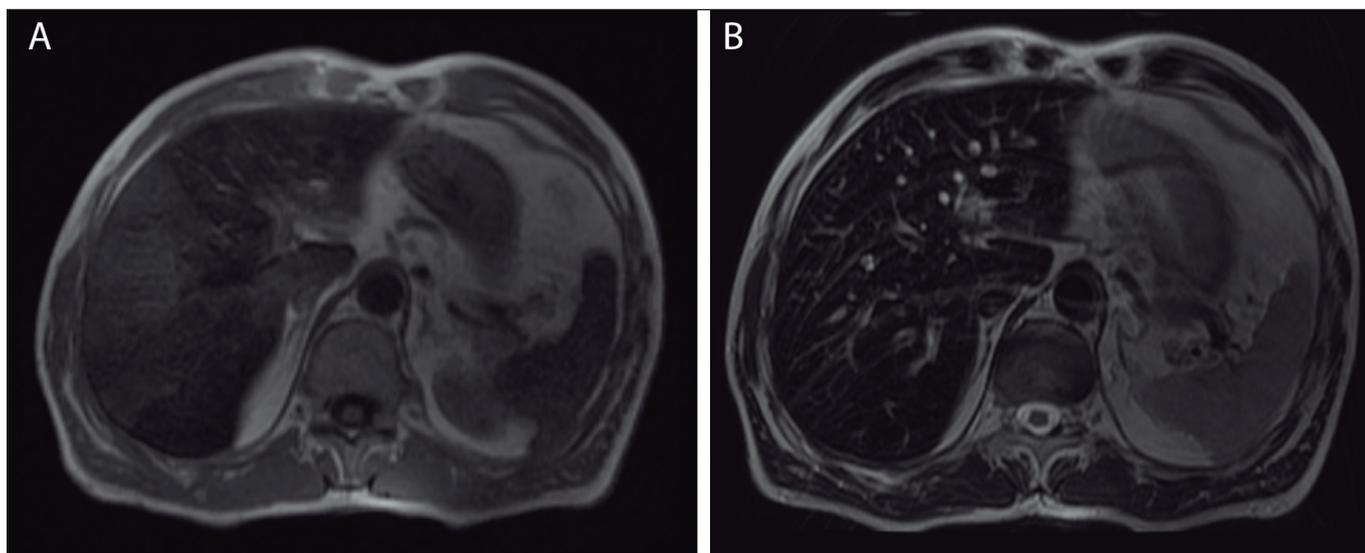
Abdominal MRI shows low-signal intensities in the liver parenchyma both in T1 (A) and T2 (B), suggesting iron deposition.
